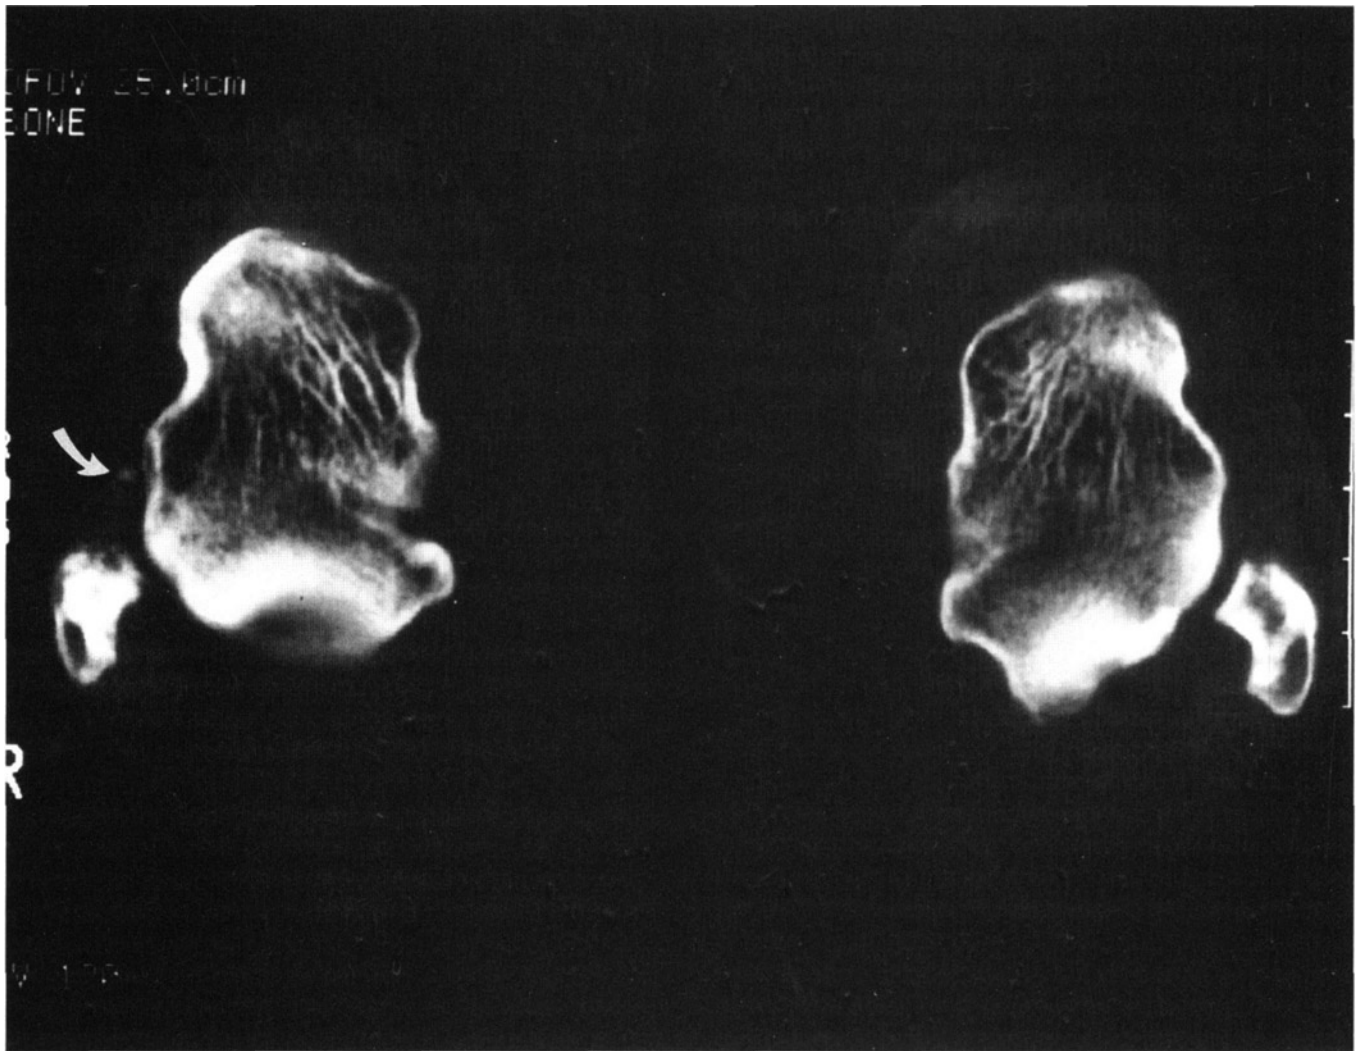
CT scan with axial slice through the talus at the level of the exostosis.
